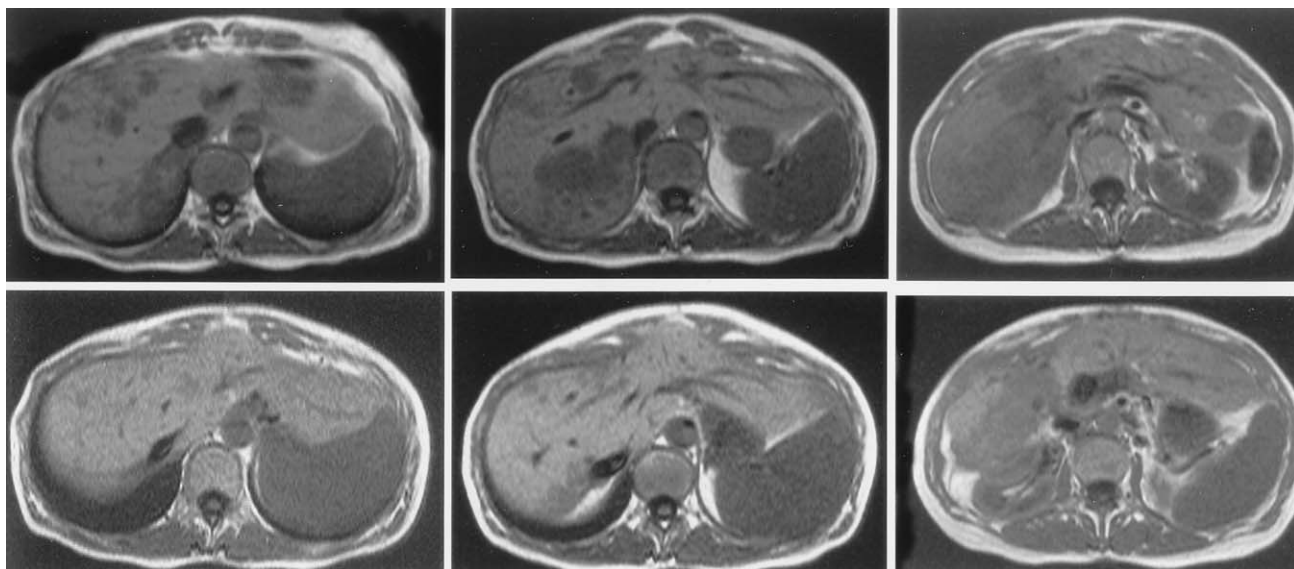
Pre- and post-treatment T1-weighted MRI from a patient with unresectable HCC. The patient received a 60-minute IHP. This patient achieved a partial response to therapy for 8 1/2 months. *Top three panels* are images at different levels of the liver before treatment. *Bottom three panels* demonstrate comparable areas of the liver 7 months after treatment. Note the decrease in the overall size of the liver after treatment as well as the measurable lesions.
